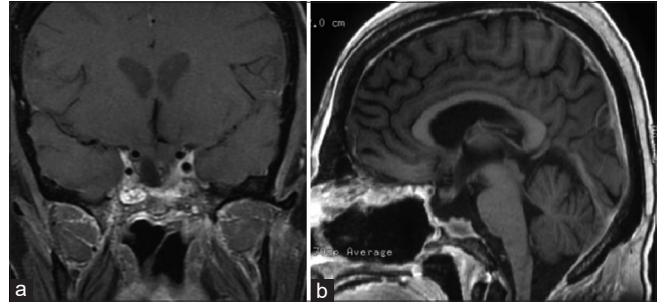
Postoperative pituitary MRI (6 months' post op): Coronal (a) and sagittal (b) images show post debulking of the previously seen large sellar and suprasellar tumor mass lesion, however residual sellar enhancing mass is noted with associated enhancing mass affecting the pituitary stalk and possibly invading the optic chiasm
